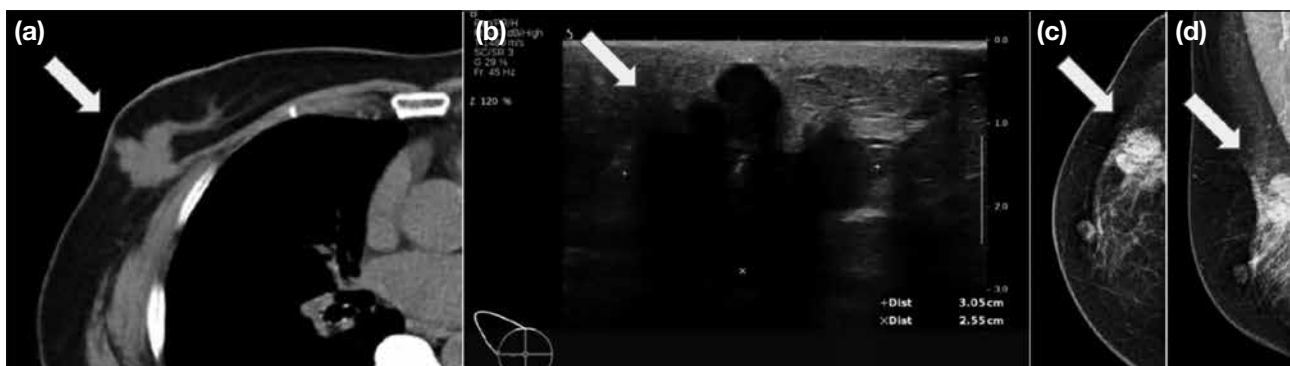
A 67-year-old woman underwent a plain computed tomography (CT) scan of the thorax for prolonged cough. (a) Axial CT scan reveals an incidental irregular shaped mass with spiculated margins in the upper outer quadrant of the right breast (arrow), with suspicious involvement of the right pectoralis muscle. (b) Ultrasound scan of the right breast confirms the hypoechoic mass with irregular shape and spiculated margin at the right 9 o'clock position (arrow). (c, d) Mammograms showing the right breast mass as a high-density irregular mass with spiculated margins that closely abuts the pectoralis muscle (arrows). Biopsy was performed and pathological examination confirmed invasive ductal carcinoma.
